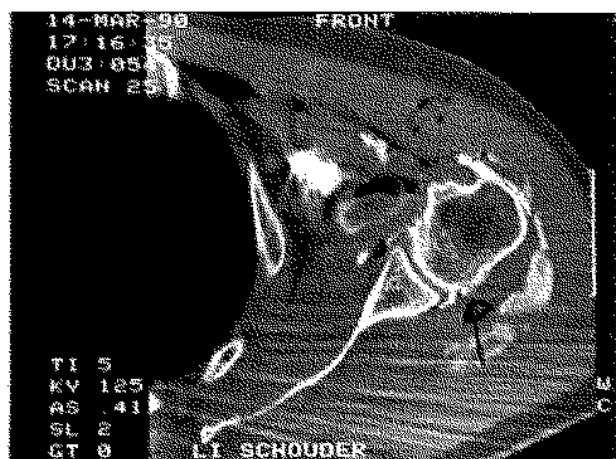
CT-scan with some possible bony involvement of the posterior side of the humeral head (arrow).
